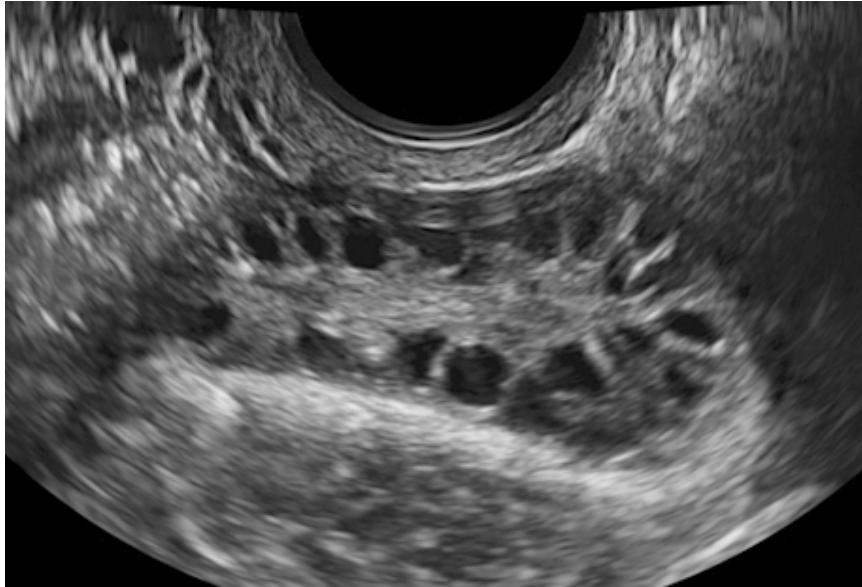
Polycystic morphology ovaries on ultrasound
